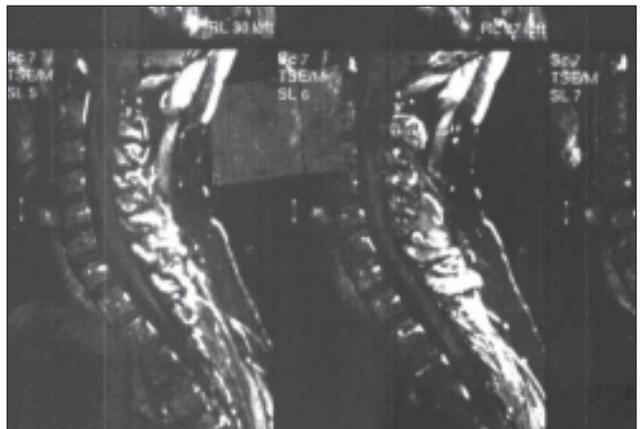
MRI of cervical spine T1
